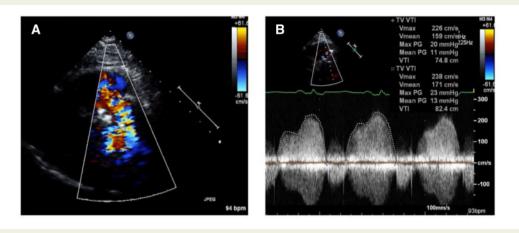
Figure I Transthoracic echo showing tricuspid stenosis, with a mean gradient of 13 mmHg.
